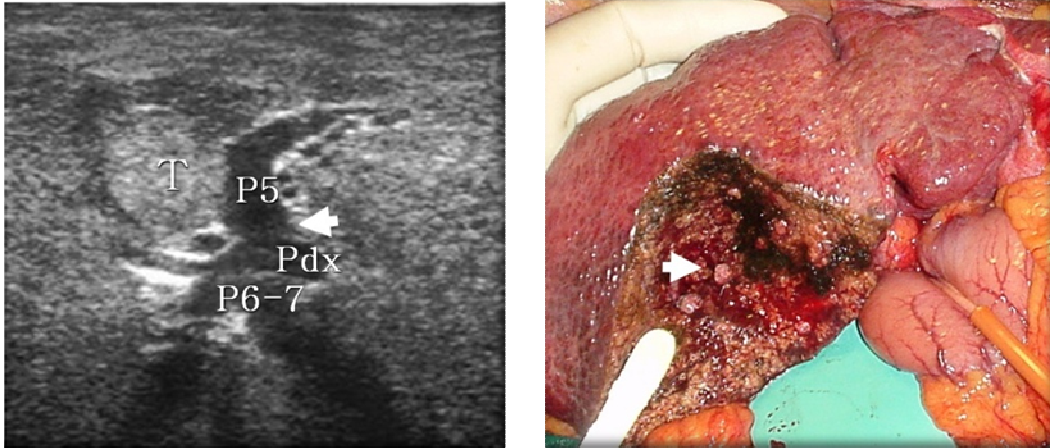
Central hepatocarcinoma (T) (right group) with type II Hi raport with P5. Intraoperative ultrasound (left) and intraoperative postresection aspect (right); the hepatic resection consisted in segmentectomy S5, with the preservation of P6-7 and P8. The arrow indicates the level of ligation of P5 (left) and the blunt of P5 exposed on the transe (right).
